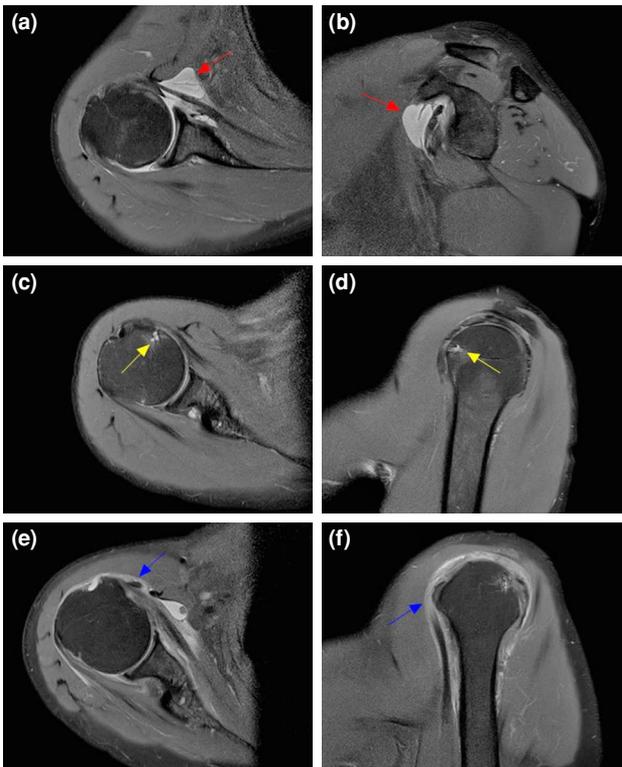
(a) The red arrow indicated coracoid bursa effusion in the transverse position of the involved shoulder MRI; (b) The red arrow indicated coracoid bursa effusion in the oblique coronal position of the involved shoulder MRI; (c) The yellow arrow indicated cysts in the lesser tuberosity in the transverse position of the involved shoulder MRI; (d) The yellow arrow indicated cysts in the lesser tuberosity in the oblique coronal position of the involved shoulder MRI. (e) The blue arrow indicated dislocation of LHBT in the transverse position of the involved shoulder MRI. (f) The blue arrow indicated dislocation of LHBT in the oblique coronal position of the involved shoulder MRI.
